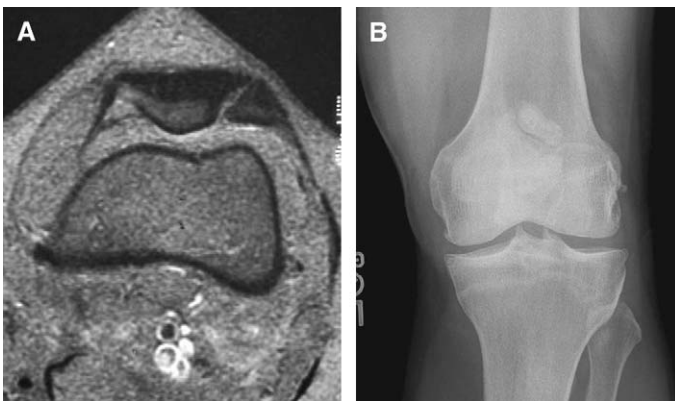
Bipartite patella. (A) Gradient echo MR image shows cleft in the superior lateral patella without evidence for edema. Corticated margins suggest the diagnosis. (B) Radiograph bipartite patella.
